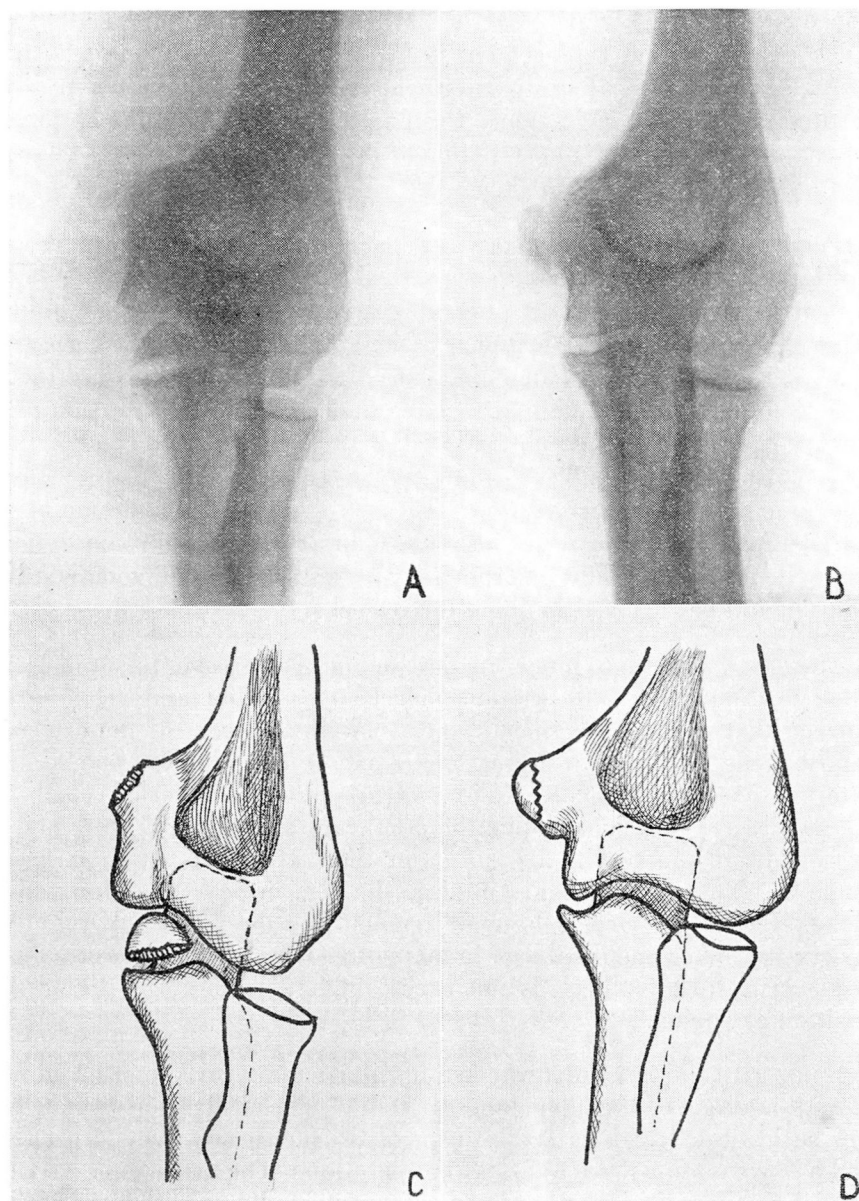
A. Fracture of the internal epicondyle in a girl of ten. Note that the epicondylar fragment has been caught in the joint space. There was evidence of slight ulnar palsy which was completely relieved following operation. B. Fracture reduced by open method. C. "Three-dimensional" reconstruction from a tracing of the roentgenogram. D. After reduction.
